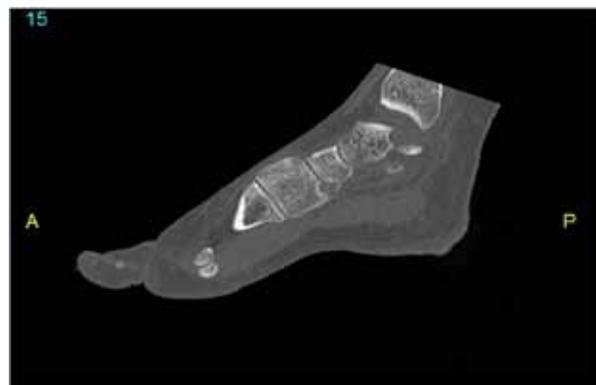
Sagittal CT image of the left foot demonstrating a sclerotic plantar articular surface at the navicular-medial cuneiform joint.
